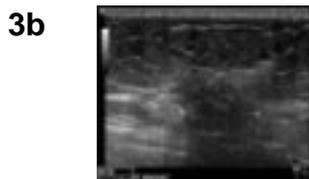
and 3b (Breast Ultrasound): An irregular, hypoechoic area of parenchyma measuring 20mm in diameter is located in the upper outer quadrant/axillary tail region of the right breast. The features are suspicious for a breast carcinoma.
